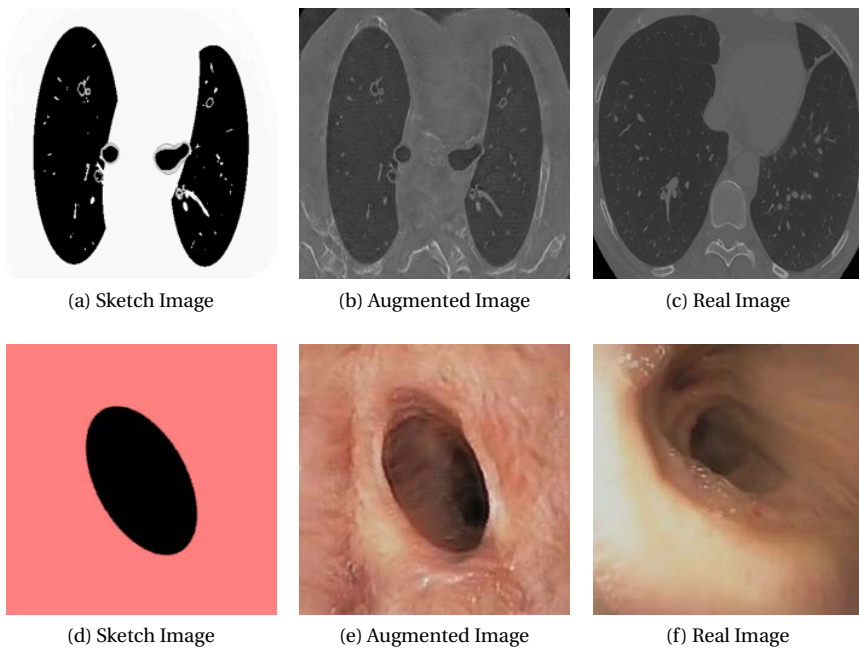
Virtual, augmented and real images for both VB and CT-scans from sketch domains.
